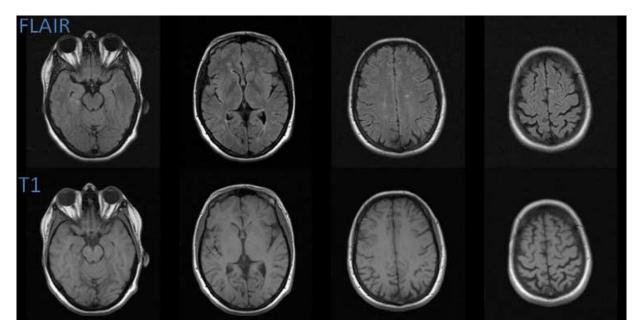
FLAIR and T1 MR images of a 44 years female with NPSLE reveal multiple focal punctuate lesions-hyperintense on FLAIR and hypointense or isointense on T1- at the periventricular and subcortical white matter, semioval center and the cortex of the left frontal lobe.
